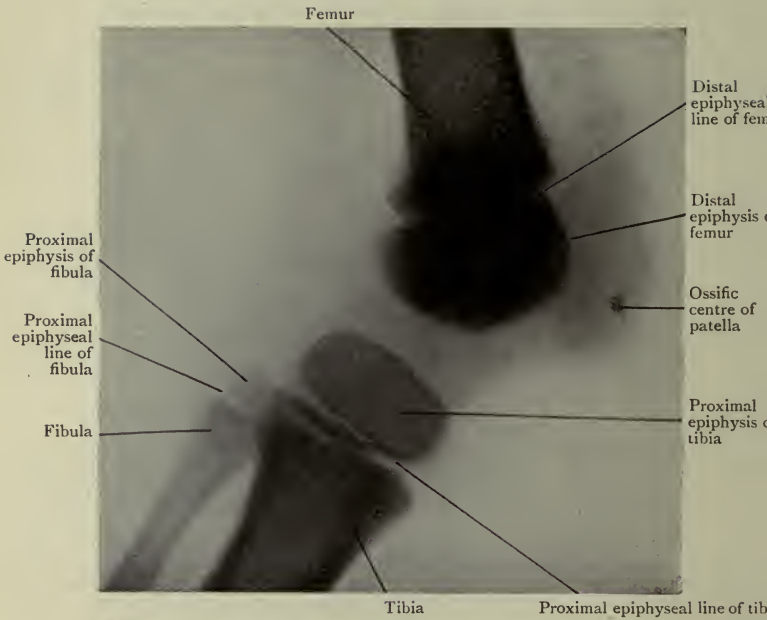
Radiograph of the Knee of a child.
